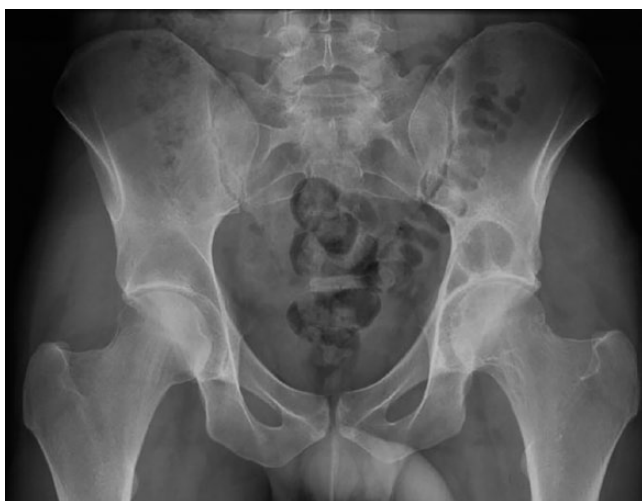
Radiography AP of the hip: at an advanced stage, the destructive nature of PVNS results in multiple and dispersed subchondral cysts.
